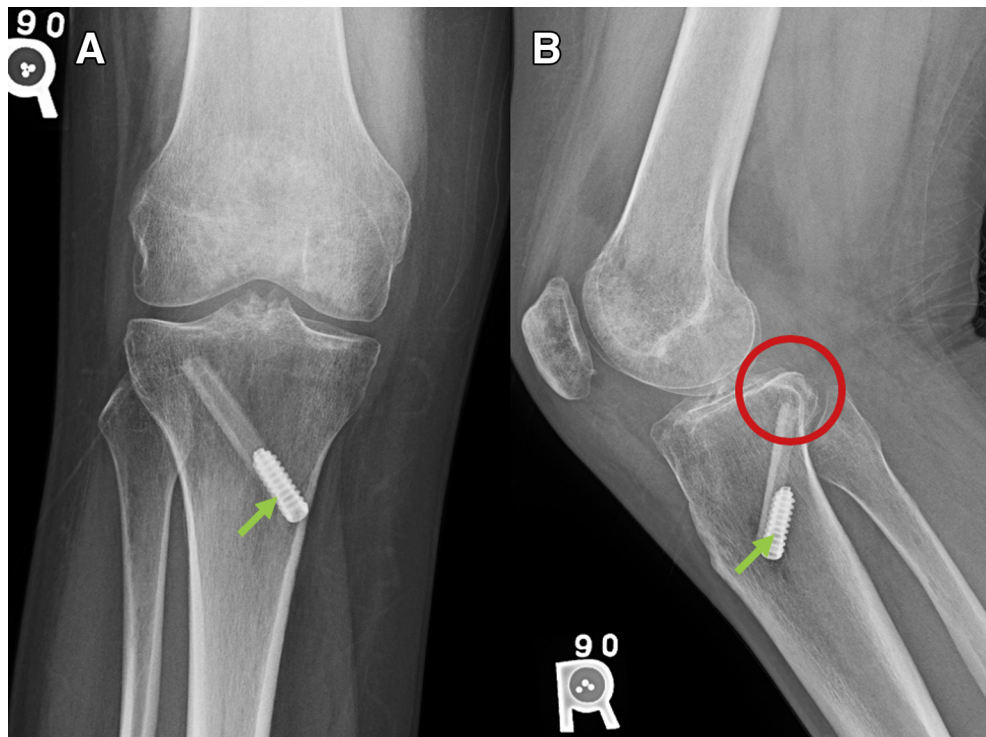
Postoperative plain radiographs, right knee, at 5 months following the procedure. Anteroposterior (B) and lateral (B) views. (A) Stable positioning of the interference screw (green arrow) is visualized. (B) Stable positioning of the interference screw (green arrow) and maintained posterolateral tibial plateau slope (red circle) are visualized.
